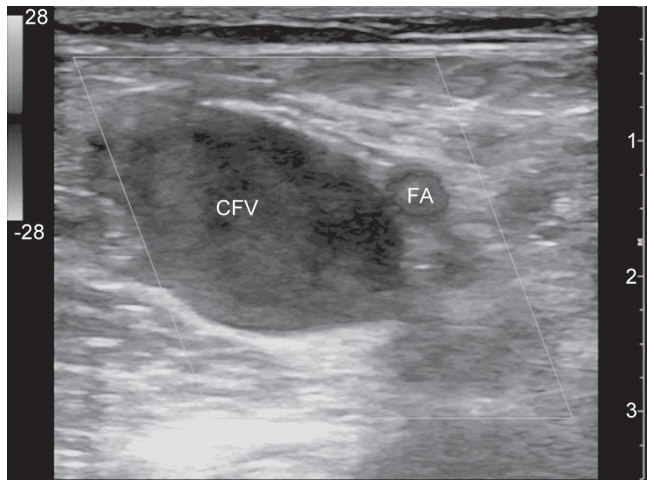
Common femoral vein (CFV) thrombosis with no flow on color Doppler.
